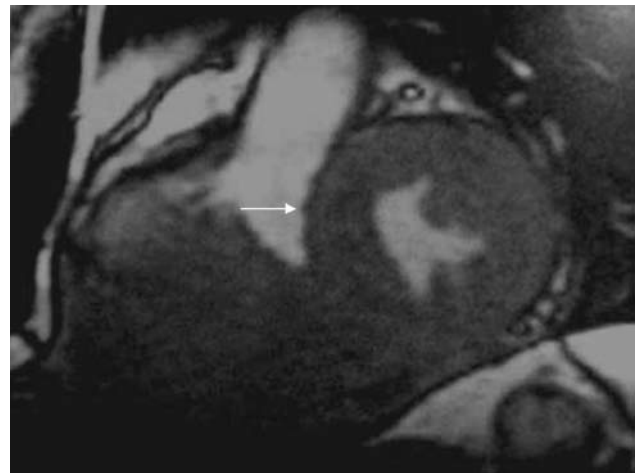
MRI: Lymphoma of the left ventricle infiltrating the myocardium.
